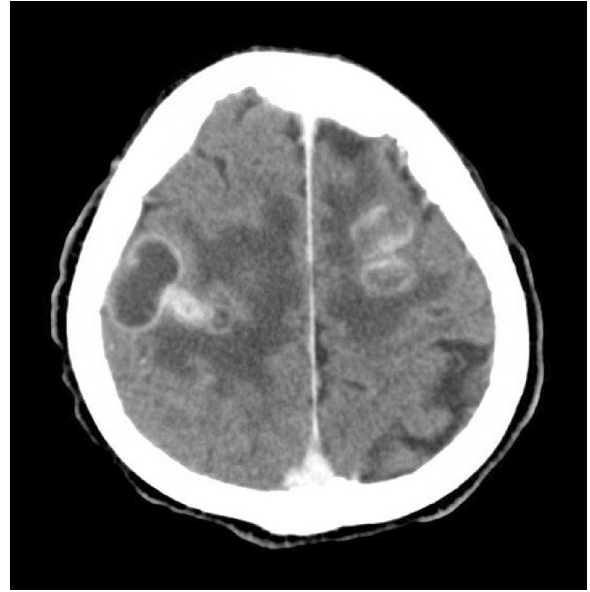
MRI T1 axial of the brain on initial presentation.
